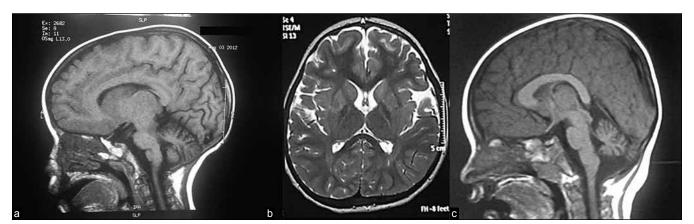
MRI images of the brain (a) T2-weighted sagittal section (Patient 1) showing mild cerebellar atrophy (b) T2-weighted axial section (Patient 2) showing hypointense globus pallidi indicative of brain iron accumulation (c) T2-weighted sagittal section (Patient 2) showing severe cerebellar atrophy
